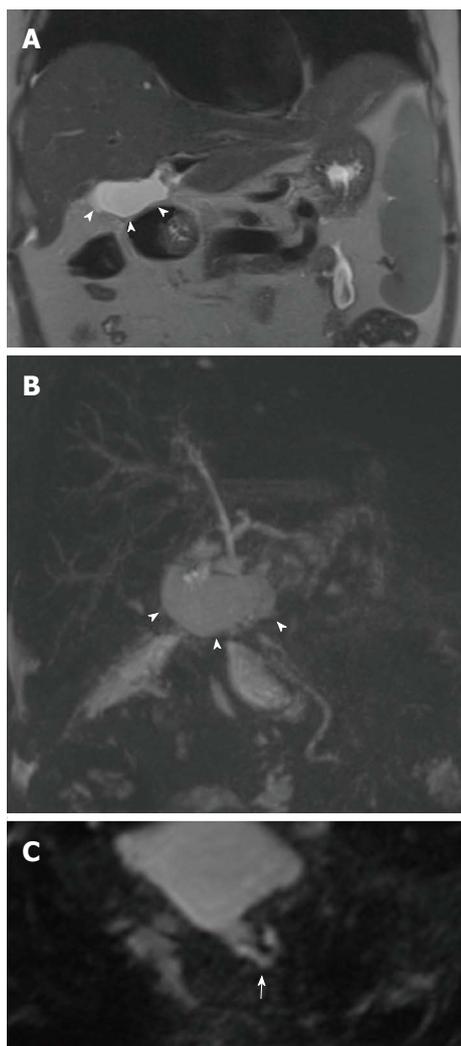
Bile leakage in a 54-year-old male subject transplanted for hepatitis C virus-related cirrhosis. Perihilar biloma shown by arrowheads on coronal T2-weighted HASTE image (A) and paracoronar MIP reconstruction from 3D MRC (B). Thin communication between the anastomotic site and fluid collection is visible on the axially-reformatted 3D source image (arrow in C). MRC: Magnetic resonance cholangiography; MIP: Maximum intensity projection.
